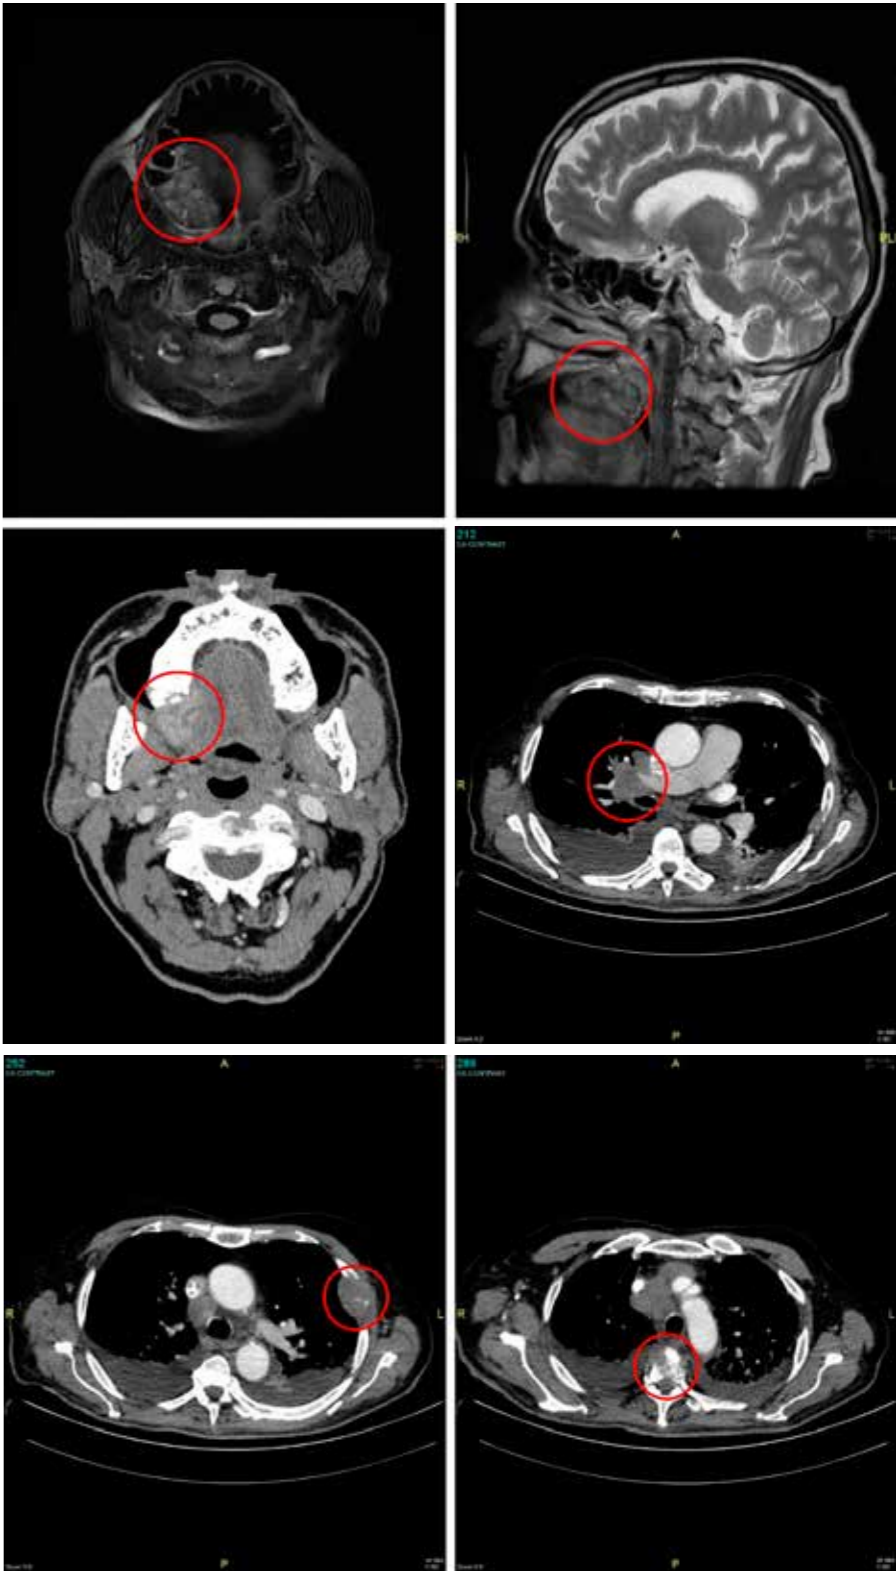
Imaging showing medullary and extramedullary involvement. Pathologies described are circled in red. (A) Axial view of MRI showing a bony lesion in the upper right palatine bone and posterior maxilla. (B) Sagittal view of MRI showing bony lesion in the upper right palatine bone and posterior maxilla. (C) Image from a bone scan showing increased tracer uptake on the right maxilla, posterior to the molars. (D) Axial CT slice showing enlarged hilar lymph nodes on the right side. (E) Axial CT scan showing rib involvement on the left side. (F) Axial CT scan showing collapse of a collapsed thoracic vertebra.
